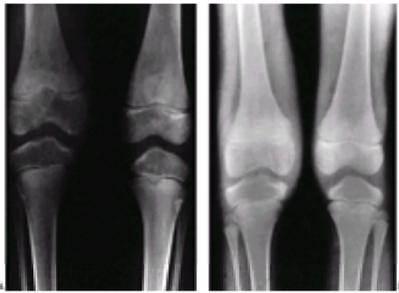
A: Anteroposterior standing radiograph of the knee in a 7-year, 2-month-old boy with factor VIII deficiency. Early changes of hypertrophic synovitis and hemophilic arthropathy are present in the right knee. Note the widening of the intercondylar notch. B: Anteroposterior standing radiograph of both knees 8 months later. The arthropathy has progressed despite good compliance with home transfusion therapy and 6 months of prophylactic transfusions. Significant joint narrowing and cartilage erosions are observed in the right knee. (From ref. [79](#), with permission.)
